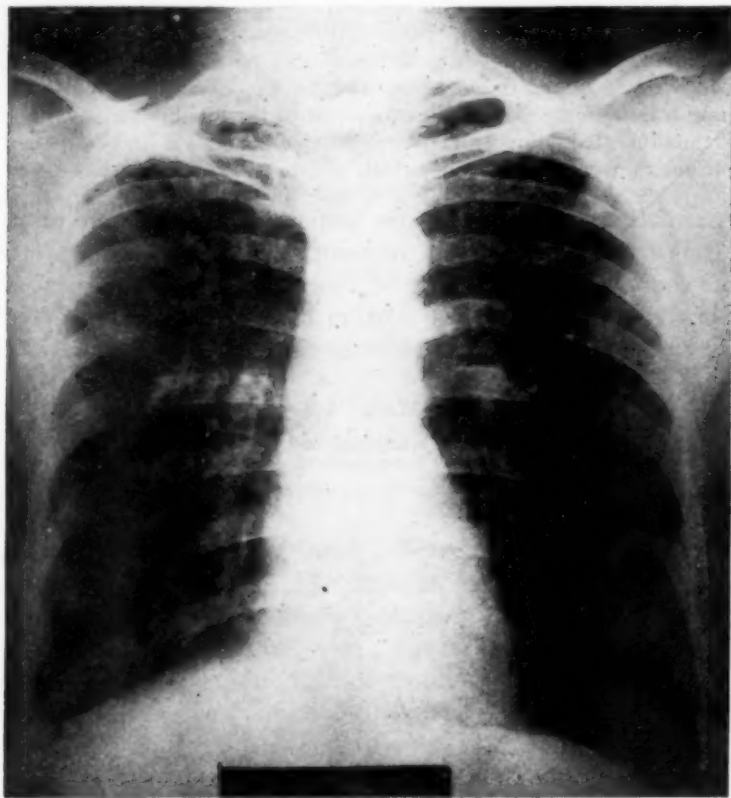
Chest roentgenogram of patient 72, B. M. Findings for left lung in per cent of total. Oxygen intake: 43; tidal air: 51; vital capacity: 54.
